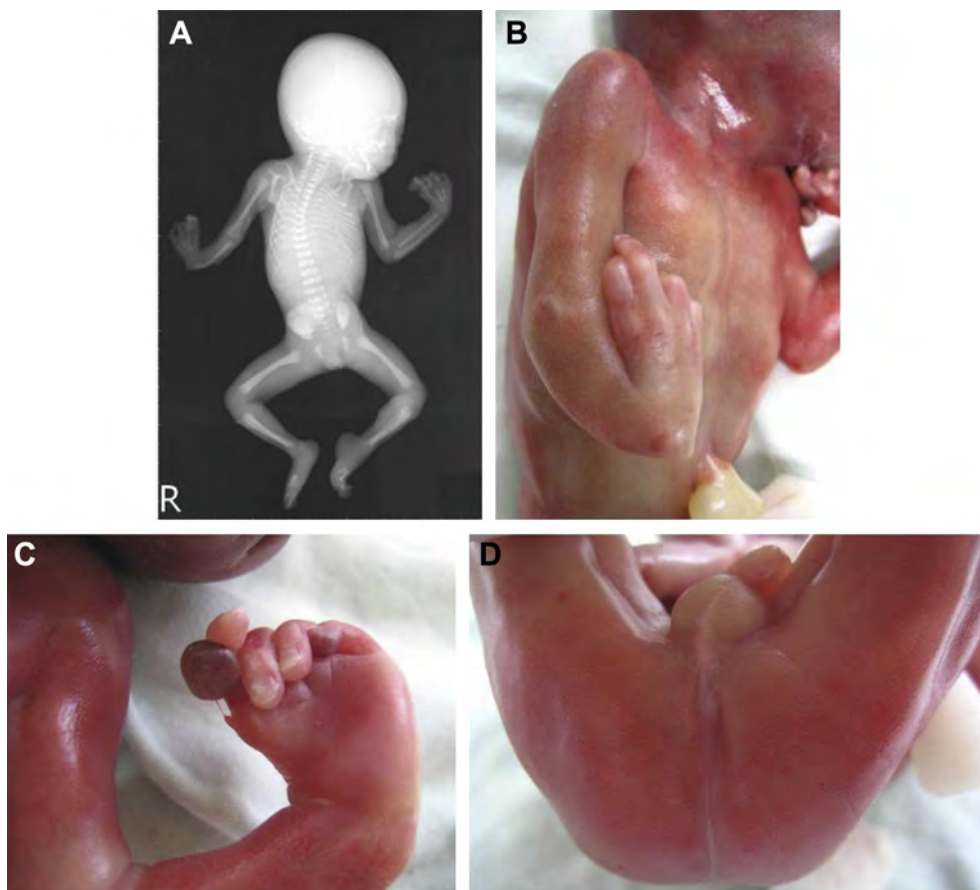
(A) X-Ray of the fetus at birth. (B) Radial ray defects of the right upper limb and absence of the right thumb. (C) Left thumb hypoplasia. (D) Imperforate anus.
